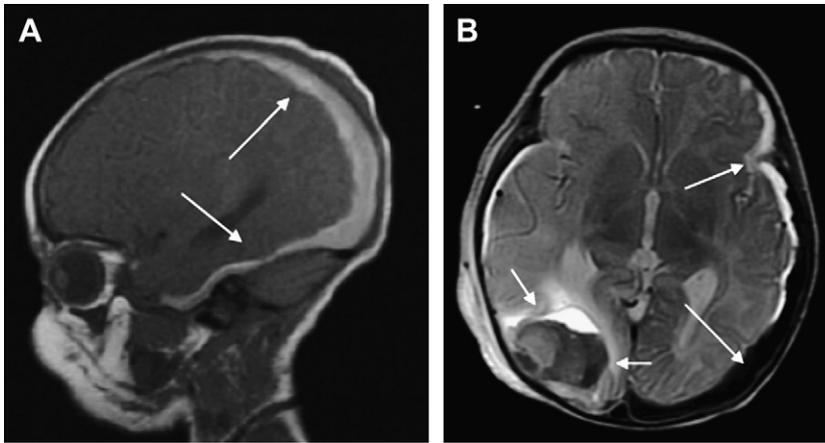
Home-delivered newborn with seizures at 1 week of age; also, no vitamin K given at birth. T1 (A) and T2 (B) MR imaging shows acute-subacute left SDH (*long arrows*) plus right cerebral hemorrhage (*short arrows*); vitamin K deficiency confirmed and treated.
